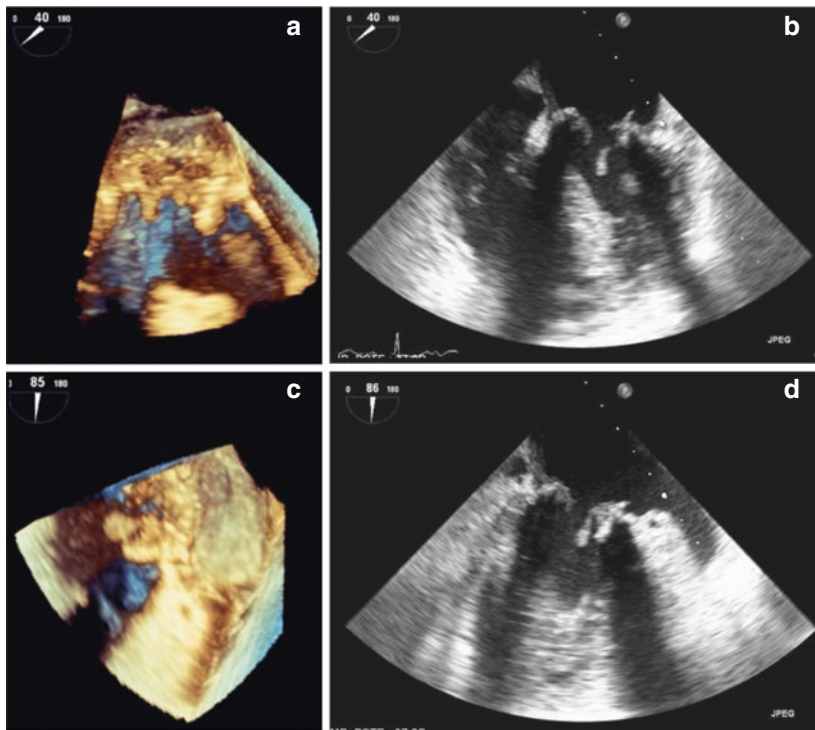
Transesophageal echocardiogram: 3D (a and c) and 2D (b and d) images; white arrow showing thrombus in the biological prosthetic mitral valve
